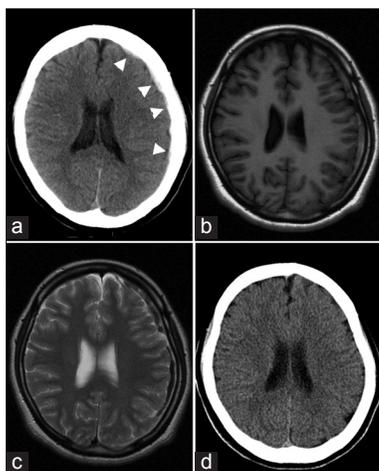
(a) Computed tomography showing a left-sided acute or early subacute subdural hematoma (arrow heads). (b) T1-weighted and (c) T2-weighted images at a day after admission. (d) Computed tomography at 1-month follow-up
